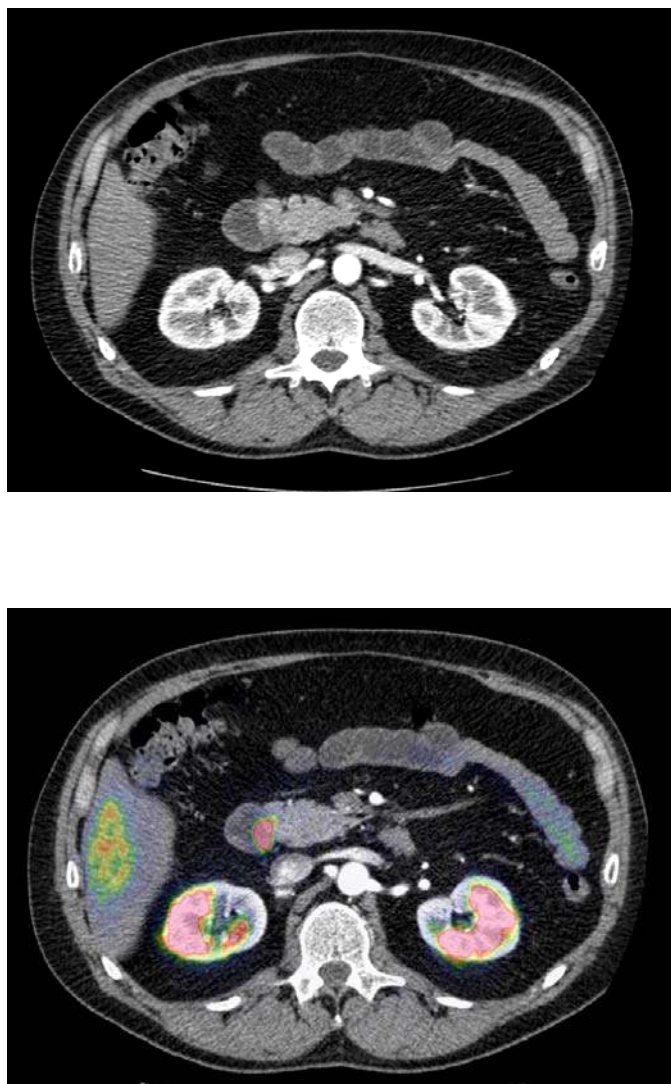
A. Transverse i.v. contrast-enhanced CT in the arterial phase showing a duodenal NET contrast-enhancing NET (arrow) surrounded by water in the duodenum. B. This tumor was also depicted by <sup>68</sup>Ga-DOTATOC-PET/CT shown in the PET/CT-fusion image.
